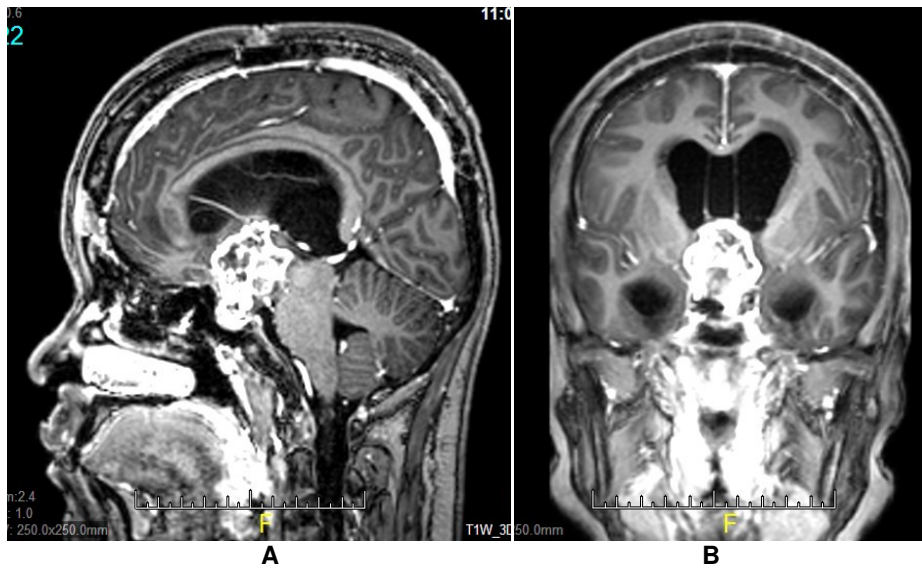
MRI of the brain showing recurrence of her tumour one year after surgery
